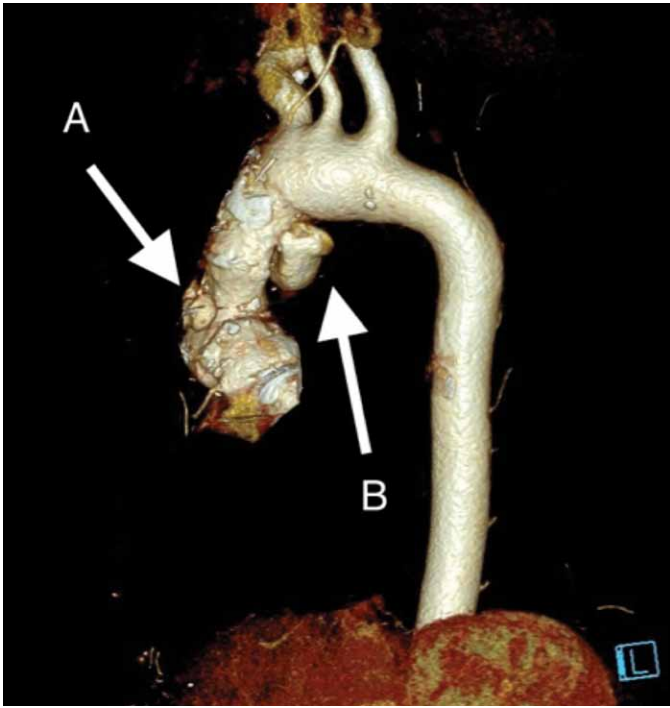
A multislice computed tomography reconstruction of aortography showing both pseudoaneurysms (A and B).
